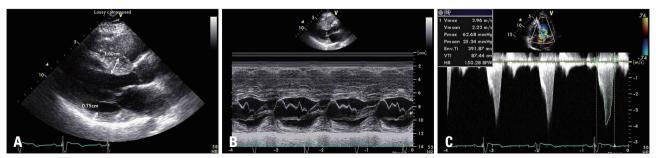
Baseline echocardiogram showed asymmetric septal hypertrophy of left ventricle in parasternal view (A), systolic anterior motion of mitral valve presented by M-mode (B), and left ventricular outflow tract (LVOT) flow pattern with dagger shape and resting pressure gradient via LVOT (C).
